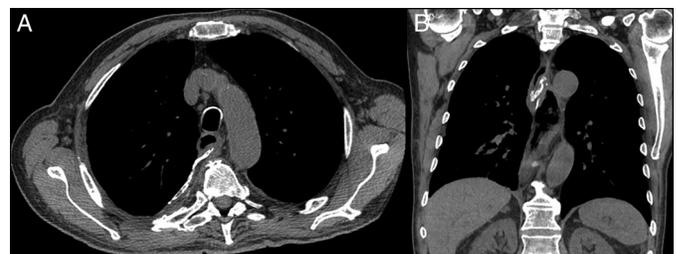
Chest CT showing (A) heterotrophic ossification of the intercostal muscle flap with resultant esophageal luminal narrowing, and (B) heterotrophic ossification of the intercostal muscle flap.
